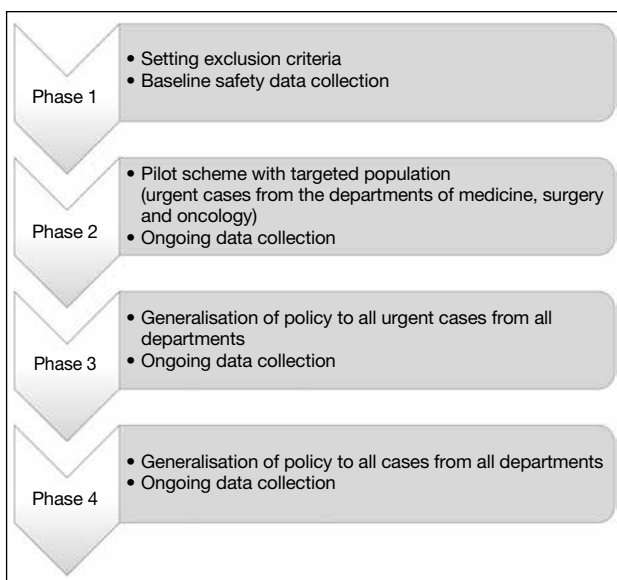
Action plan of policy change towards abolishment of preparatory fasting for contrast-enhanced computed tomography in Prince of Wales Hospital.
